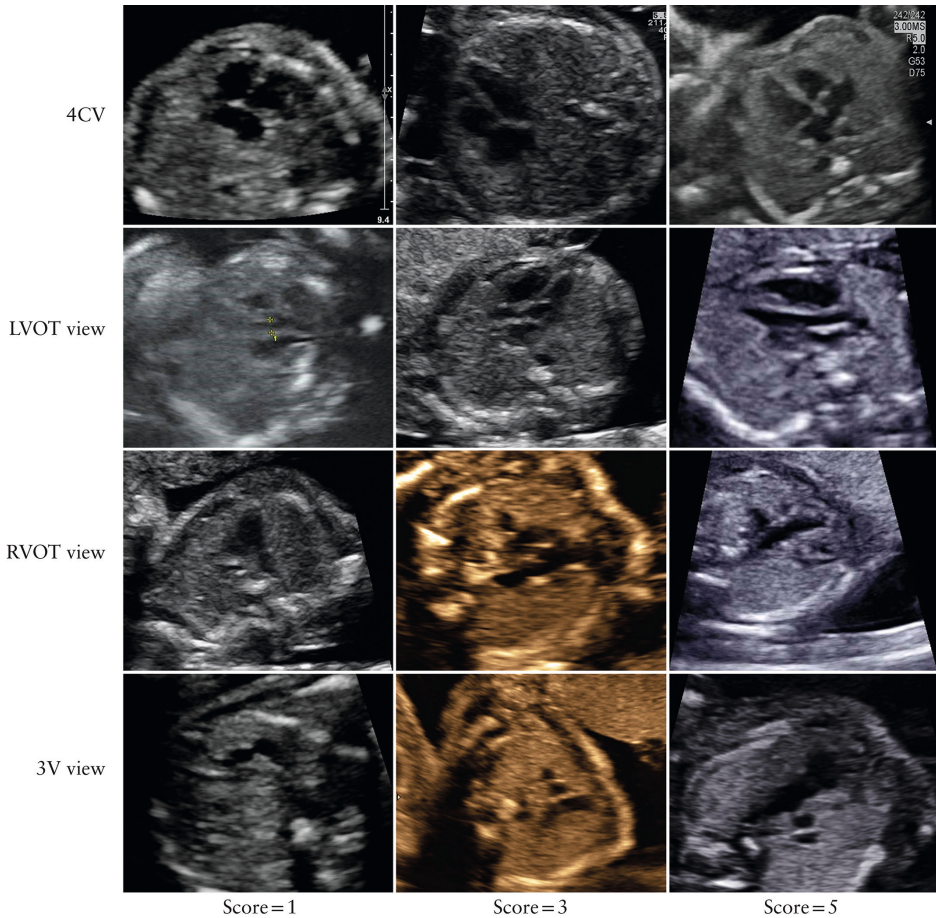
Visual scoring system. Examples of ultrasound images of the fetal heart in four-chamber (4CV), left ventricular outflow tract (LVOT), right ventricular outflow tract (RVOT) and three-vessel (3V) views, that obtained quality score of 1, 3 or 5, in cases with severe congenital heart disease at birth.
